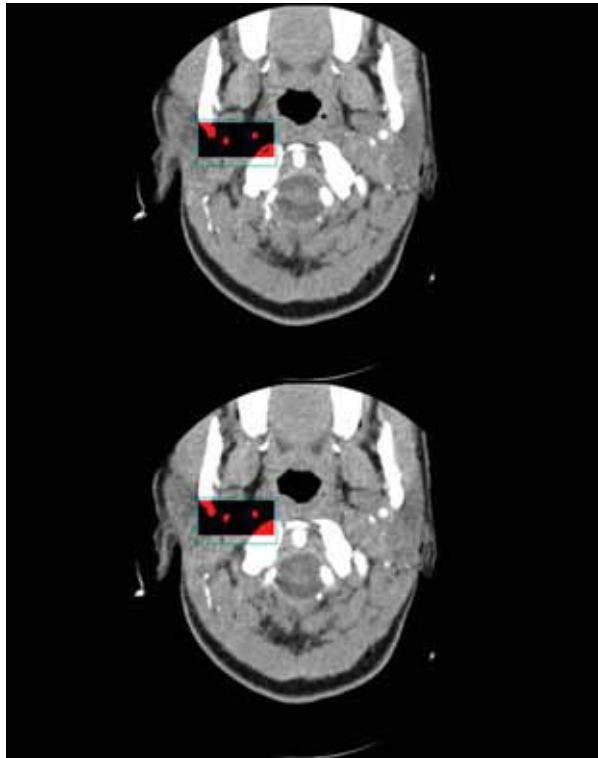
Sample of actual CTA images where regions of interest (ROI) have been segmented.
